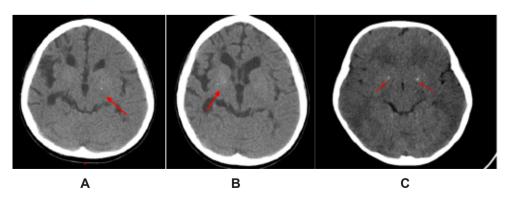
Computed tomography of patients with spondyloenchondrodysplasia and brain calcifications
